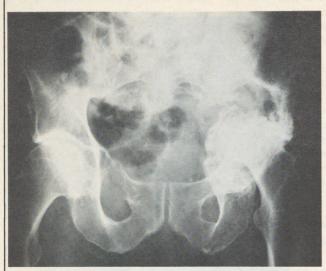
AP radiograph of pelvis of a 68-year-old male with a hypernephroma. There is a large metastatic lesion involving the left hip. There is widespread destruction of the acetabulum with a central dislocation of the femoral head.
